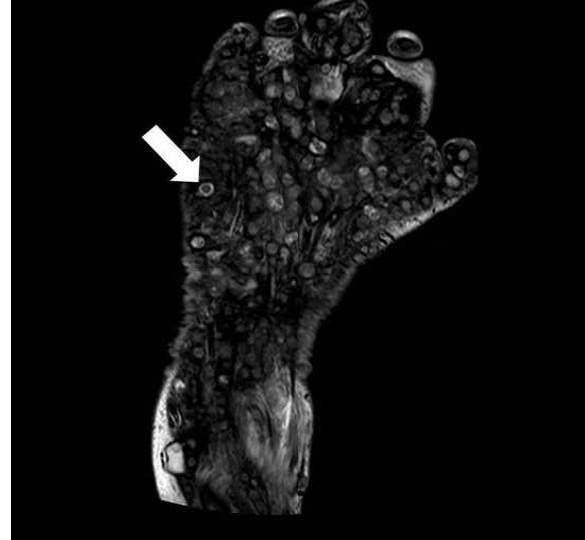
MRI image showing multiple dot-in-circle lesions which represent the colonies of the organism.
